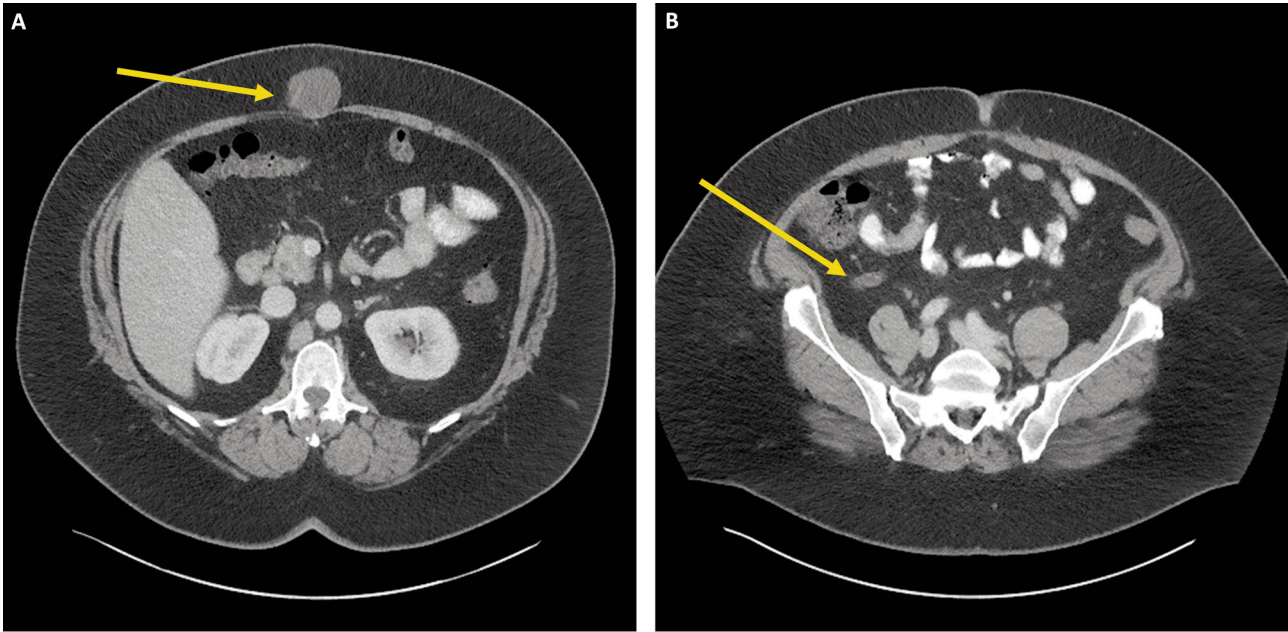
Computerized tomography (CT) images of low grade appendiceal mucinous neoplasm and abdominal wall involvement. (A) A loculated cystic fluid collection in the subcutaneous fat of the anterior abdominal wall at the midline. No obvious fascial defect. (B) Appendix is dilated to 1 cm and filled with fluid, without fecalith. There is no inflammatory change of the surrounding tissue.
